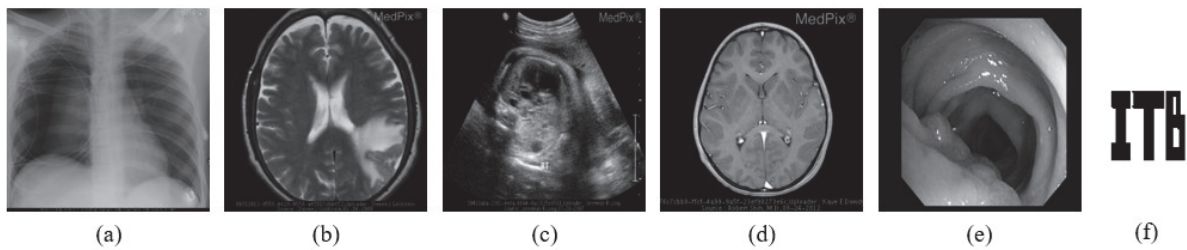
Five modalities of original medical image and a watermark (a) X-ray , (b) CT, (c) US, (d) MRI, (e) Colonoscopy, (f) watermark.
